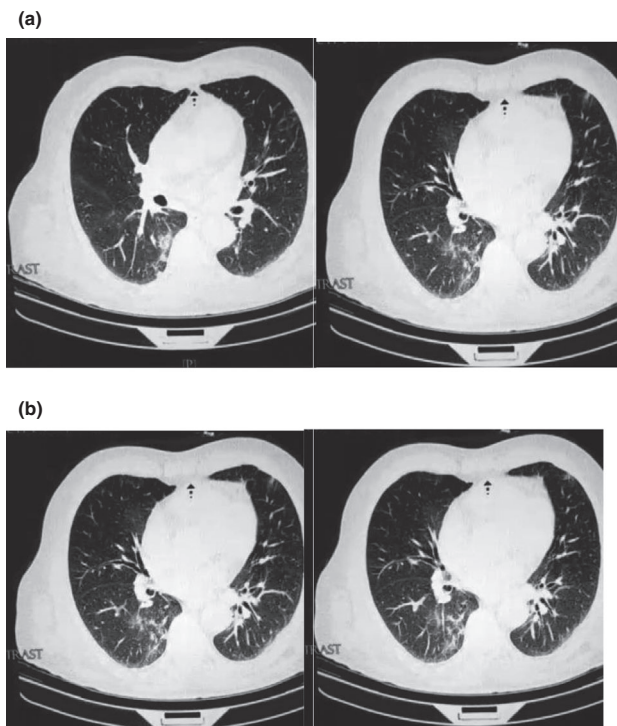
Patient CT chest at the time of hospital admission (a-d).
